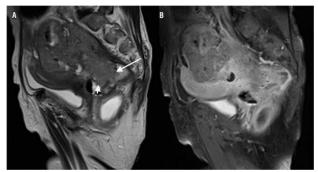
(A) MRI sagittal sequence with T2 information and (B) sagittal sequence with T1 information after intravenous administration of contrast medium. Heterogeneous mass involving the wall of the rectum (long white arrow), the vaginal vault (short white arrow) and the posterior wall of the uterus with growth towards the abdominal cavity, which presents heterogeneous enhancement with contrast medium.
